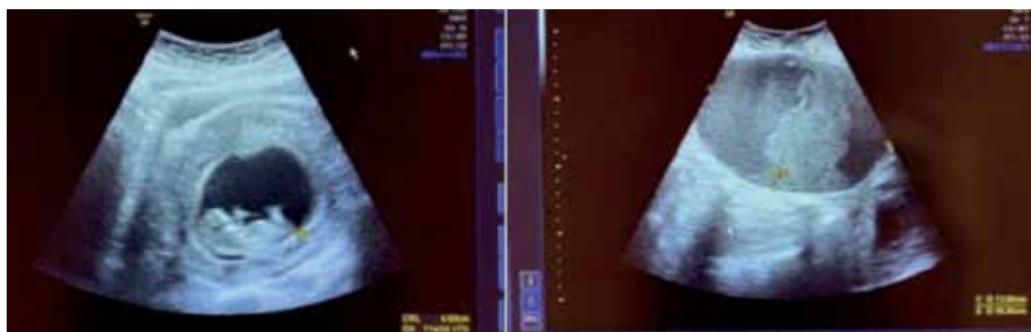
Ultrasonography from Case 1 revealed a singleton living intrauterine fetus at 11-12 weeks of gestation with a multilocular hypoechoic mass
